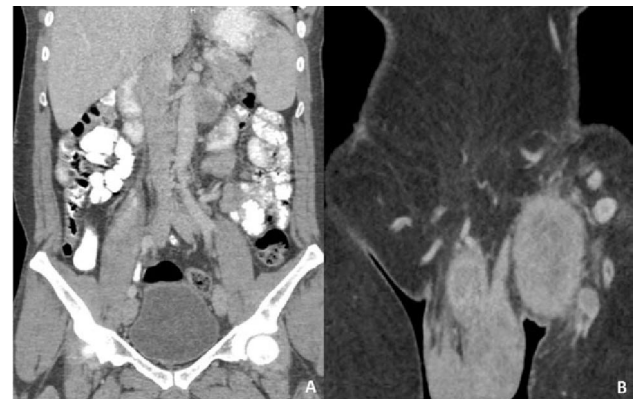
Coronal contrast enhanced CT scan of abdomen and inguino-scrotal region. (A) Heterogeneously enhancing left para-aortic lymph nodes. (B) Coronal Enlarged and bulky left testis due to a heterogeneously enhancing solid mass with central non enhancing necrotic areas.
